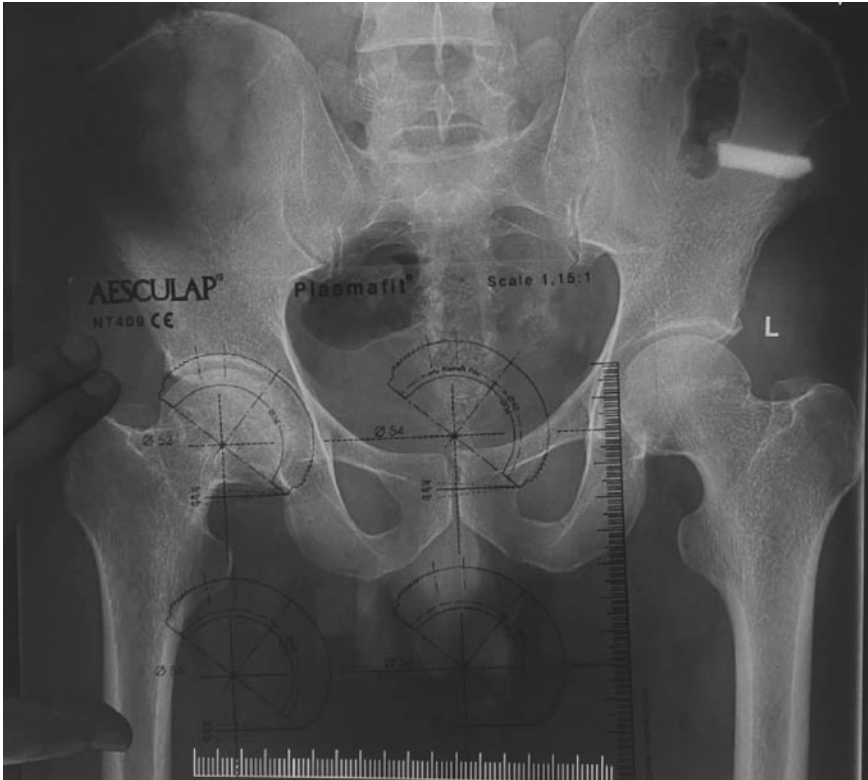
X-ray of both hips with pelvis in a patient with right hip arthritis showing templating for the right acetabular component
